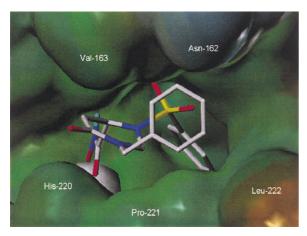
X-ray structure of a complex of 4e with truncated stromelysin.
